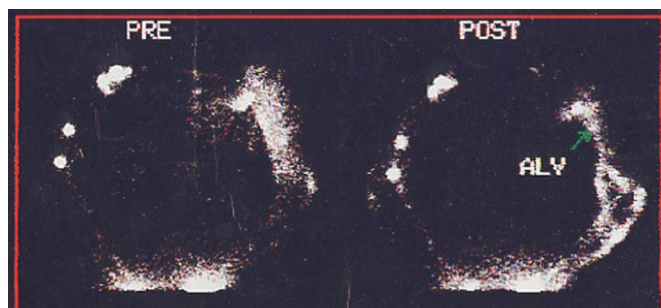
Lymphoscintigraphic demonstration of patency of lymphatic-venous anastomoses. Marked reduction of dermal backflow, appearance of preferential lymphatic pathways, disappearance of the tracer at the site of microanastomoses (Lymphoscintigraphy performed by Nuclear Medicine Unit, University of Genoa).
